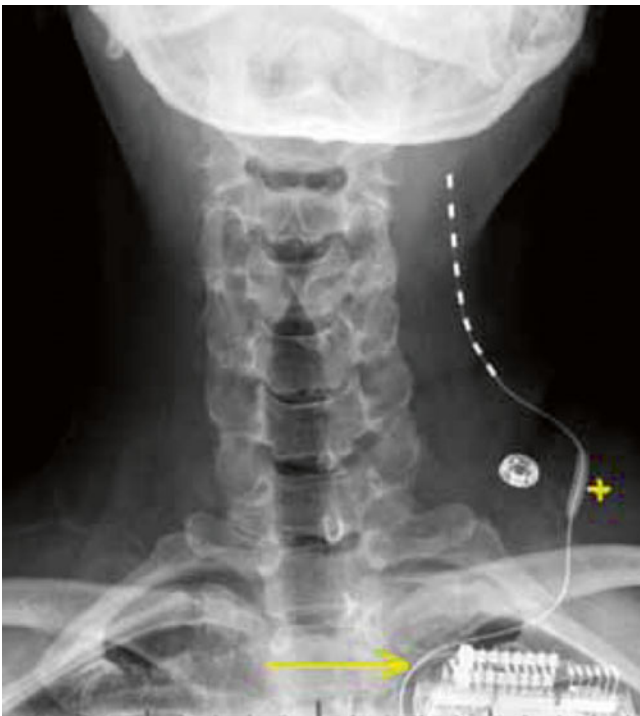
X-ray image of a percutaneous peripheral nerve stimulator placed over the great auricular nerve (From Elahi and Reddy [20]. Reprinted with permission from the American Society of Interventional Pain Physicians)
